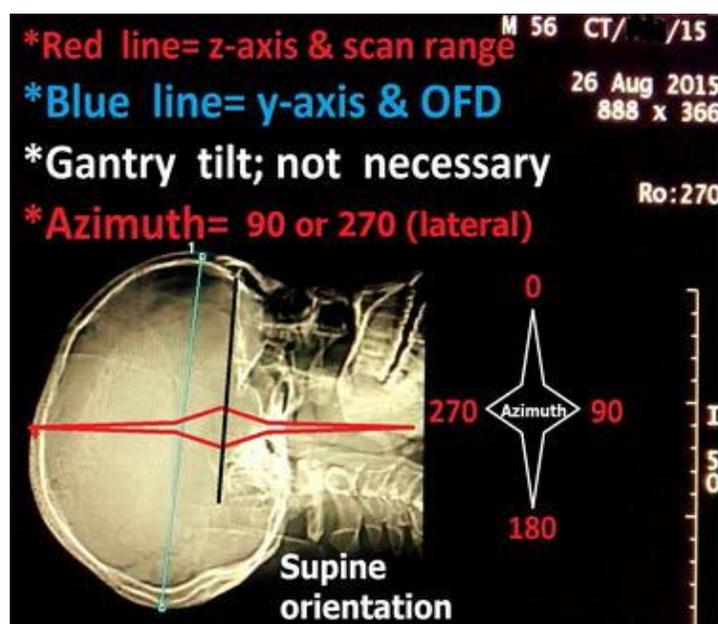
Lateral scanogram generated at 90 degree azimuth is used for measurement of OFD. Base of skull (drawn, dark, suspended, vertical line) must be perpendicular to horizontal CT couch to indicate perpendicularity of cantho-meathal line and to avoid gantry tilt which is a stress on machine. If head is well positioned during image acquisition, blue horizontal line should maintain an azimuth of 180 degree, otherwise, it should be parallel to BOS
